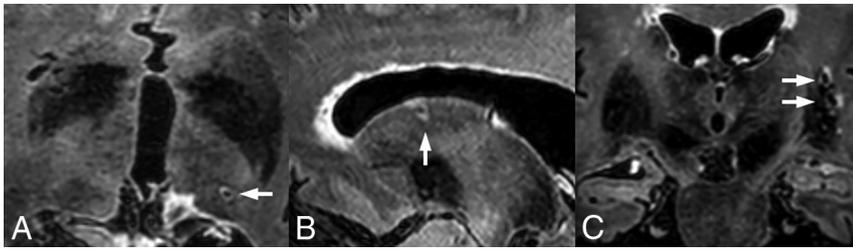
Examples of microinfarcts in the deep gray matter on 7T MR imaging. A, Microinfarct with a diameter of 2.3 mm (arrow) in the left thalamus of a 73-year-old woman on transversal 7T FLAIR. B, Microinfarct with a diameter of 2.9 mm (arrow) in the left caudate nucleus of a 64-year-old man on sagittal 7T FLAIR. C, Two microinfarcts with diameters of 3.0 and 3.2 mm (arrows) in the left putamen of a 65-year-old man on coronal 7T FLAIR. Note that the gliotic rim extends into the adjacent external capsule.
